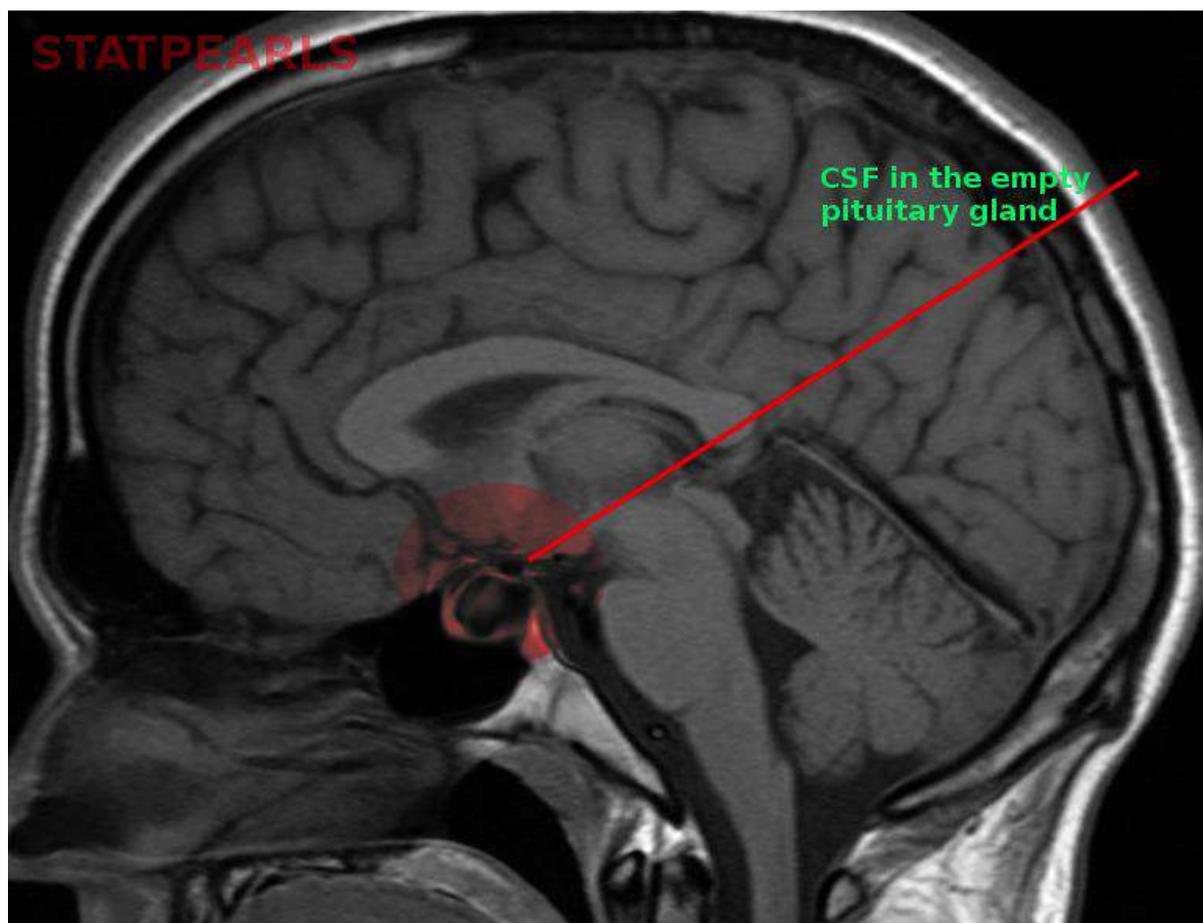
Empty Sella on MRI. Cerebral spinal fluid fills the sella turcica and empty pituitary gland. Image courtesy S Bhimji, MD [9]
